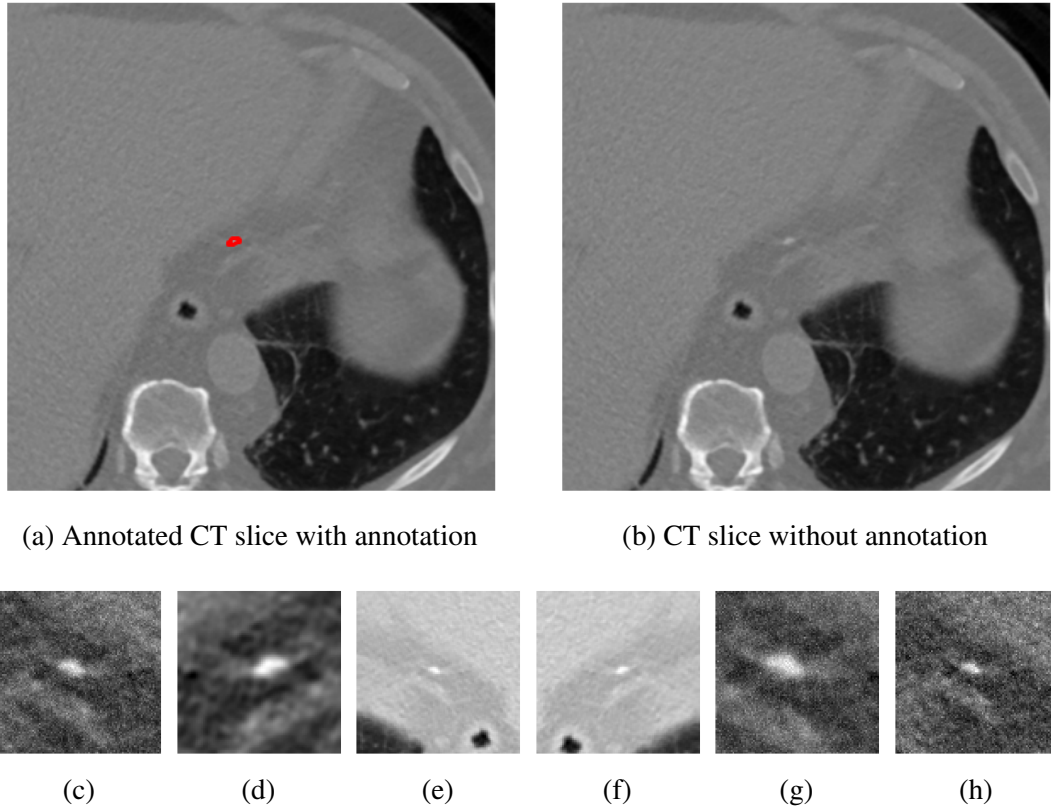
Representation of guided local data augmentation. Figure *a* represents labeled CT slice, while *b* represents the same image without annotation. The figures from *c* to *h* shows the guided local data augmentations utilized in DINO training.
